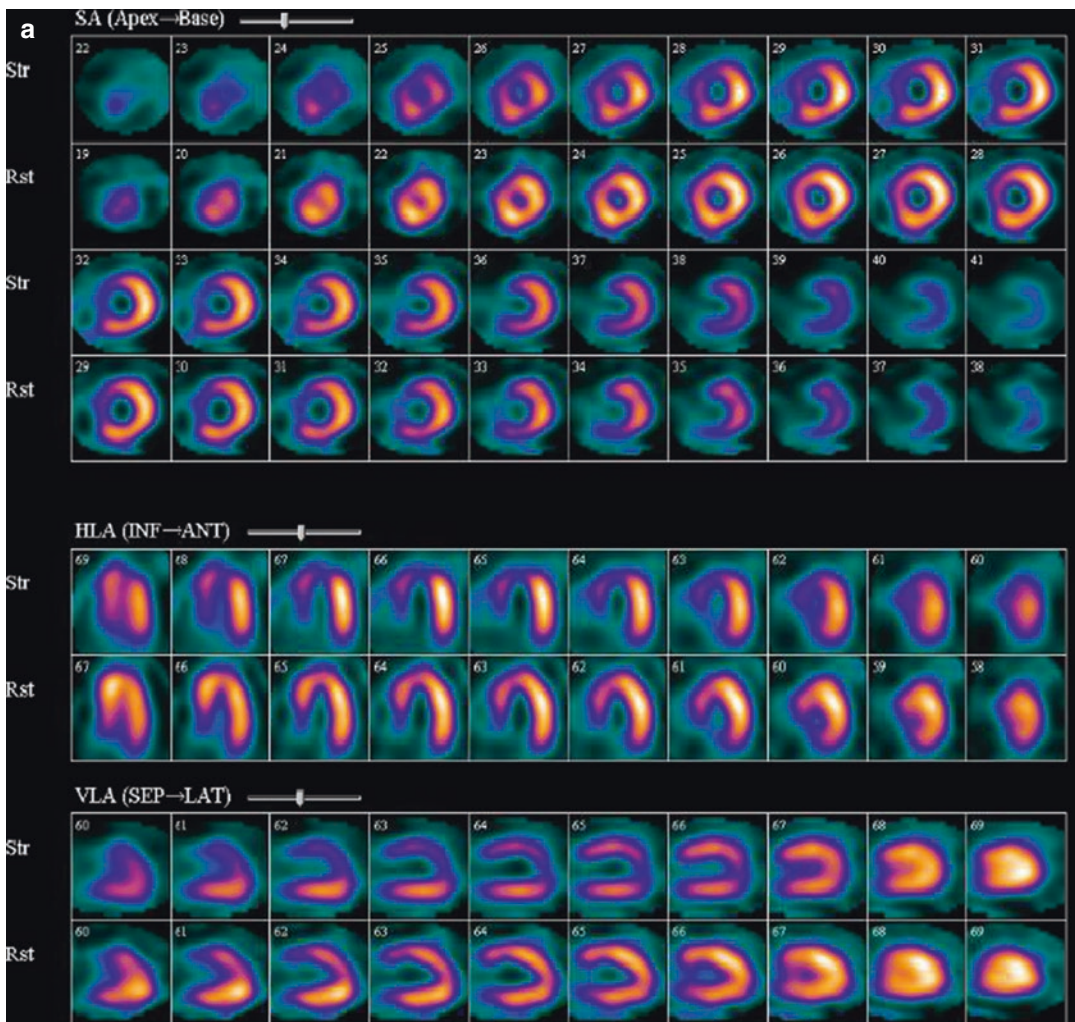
Case #3 SPECT Images (see text for details)
